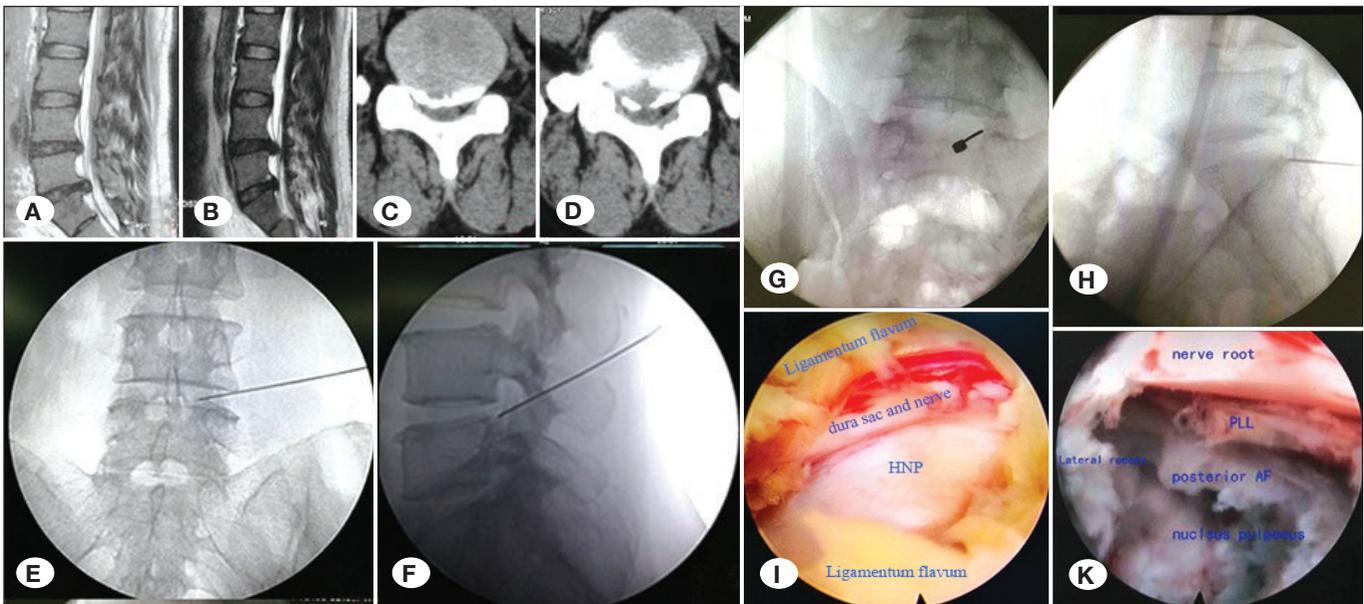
Imaging results for a male patient (30 years old) experiencing extremely serious left radicular limb pain with two-level herniation. Modified SSNB test revealed positive result for the L4–L5 segment; PETLS was performed on the L4–L5 segment. A) and B) L4–L5 and L5–S1 segments with evident herniation, respectively. C) and D) CT vertebral posterior margin amputation with calcified herniation in the L5–S1 segment. E–H) Location of needle tip in modified SSNB for L4–L5 and L5–S1. The results showed positive response for L5 nerve root and negative response for S1 nerve root. I) L5 nerve root compressed by protrusions under spine endoscopy before decompression. K) L5 nerve root after sufficient decompression.
